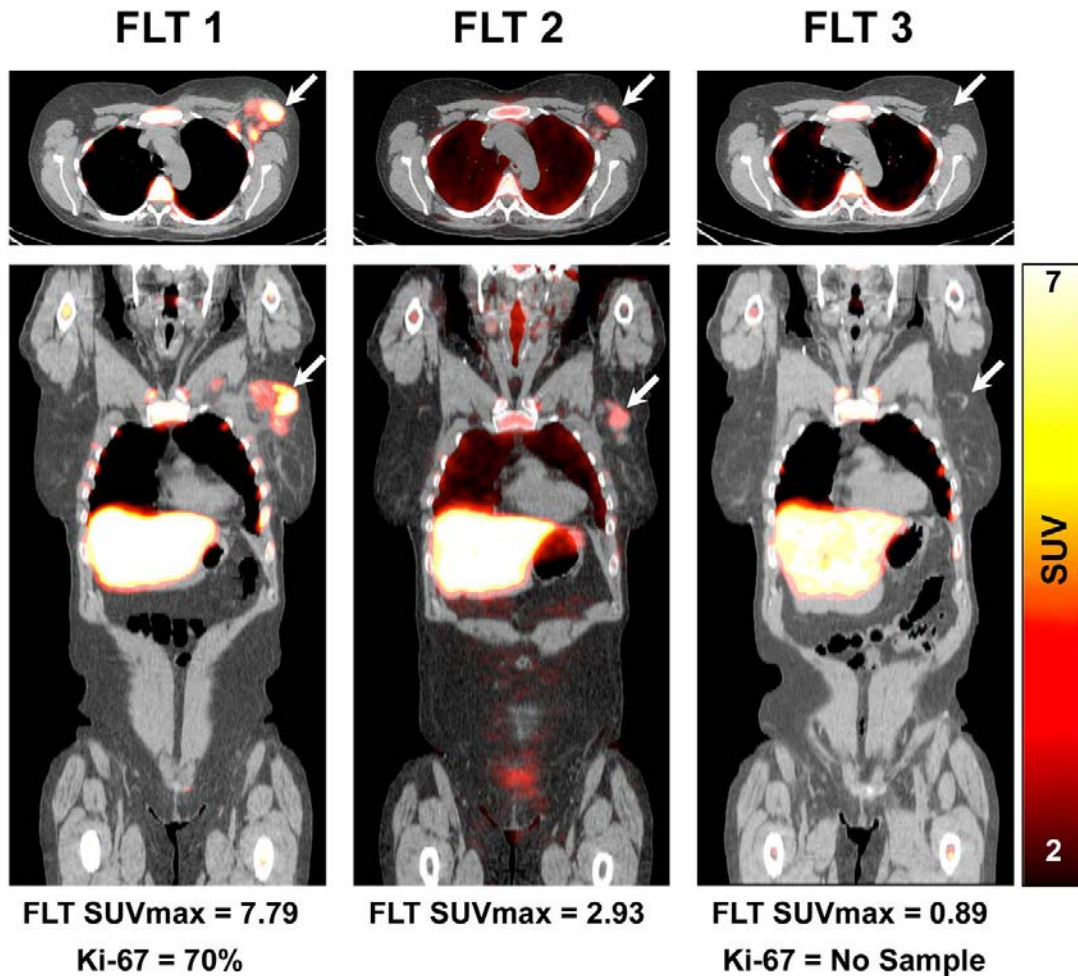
Axial (upper panel) and coronal (lower panel) ^{18}F -FLT PET/CT images demonstrating increased FLT uptake in a left upper outer quadrant primary breast cancer (arrow) and axillary lymph node metastasis before neoadjuvant chemotherapy (“FLT 1”, left panel). After one cycle of chemotherapy, there is a substantial reduction in FLT uptake (arrows, “FLT 2”, middle panel). After completion of therapy, increased FLT uptake is resolved (arrows, “FLT 3”, right panel). Pathologic complete response was confirmed at surgery. Reprinted with permission from Kostakoglu L et al, J Nucl Med. 2015;56:1681-1689. © by the Society of Nuclear Medicine and Molecular Imaging, Inc.
